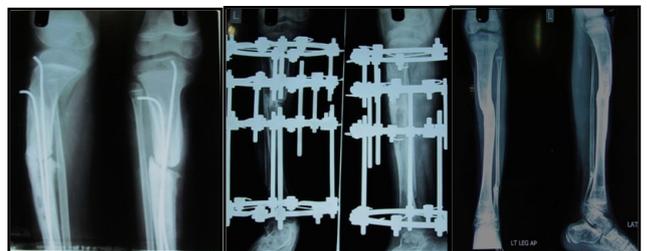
Infected non-union of tibia in a 7yr old male patient: a) Pre-operative radiographs of nonunion tibia with intramedullary implants insitu, b) Postoperative radiographs on day 64 showing evidence of early union, and c) Radiographs at 12 months showing a complete union of tibia.
